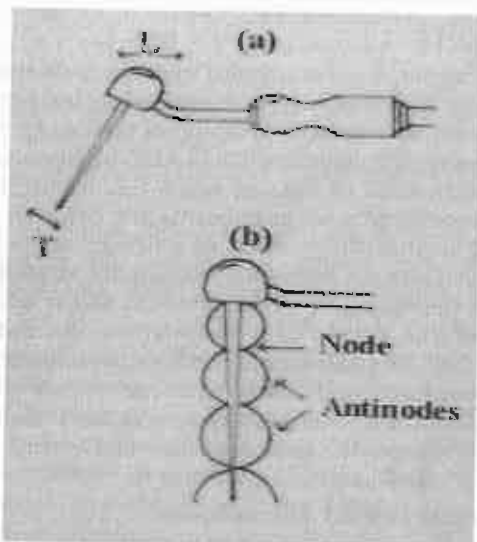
The Oscillation of the Ultrasonic instrument.
